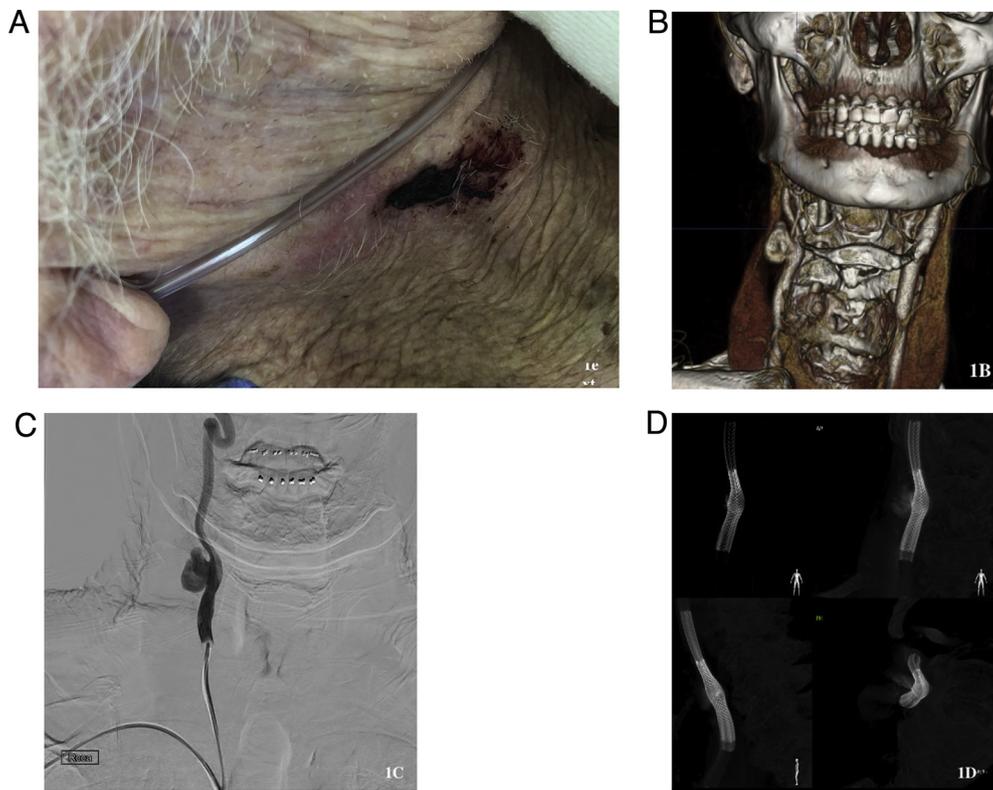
(A) Photograph of the patient's right neck eight years after carotid endarterectomy. (B) Preoperative CT showing the PA from the right CCA.(C) Digital subtraction angiography, antero-posterior view, showing a 20 × 15 mm PA originating in the right CCA bifurcation.(D) Completion angiography after stent deployment, with significant stasis within the pseudoaneurysm.
